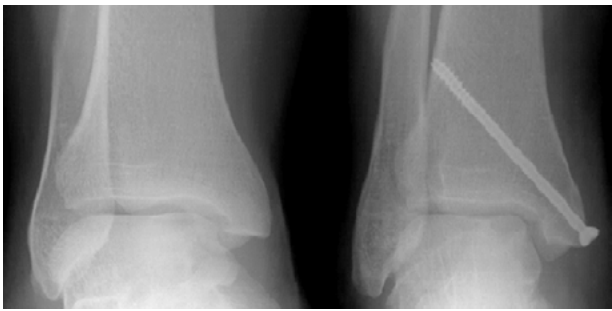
12th month anterior posterior radiograph of a patient with right talus posteromedial defect who underwent medial malleolus osteotomy. No degeneration is seen in the joint.
